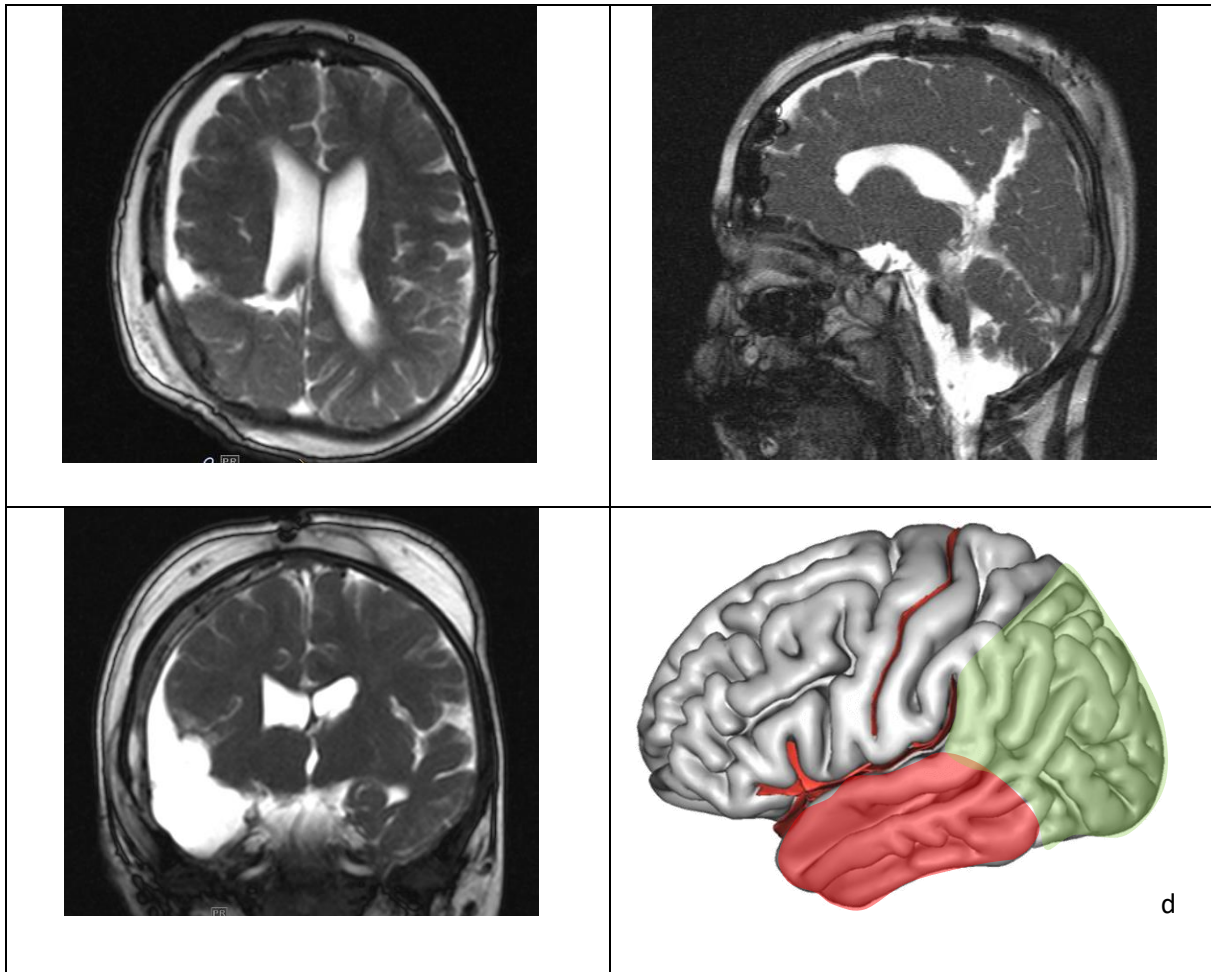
Postoperative MRI, Pat. 2, at age two years and five months.
